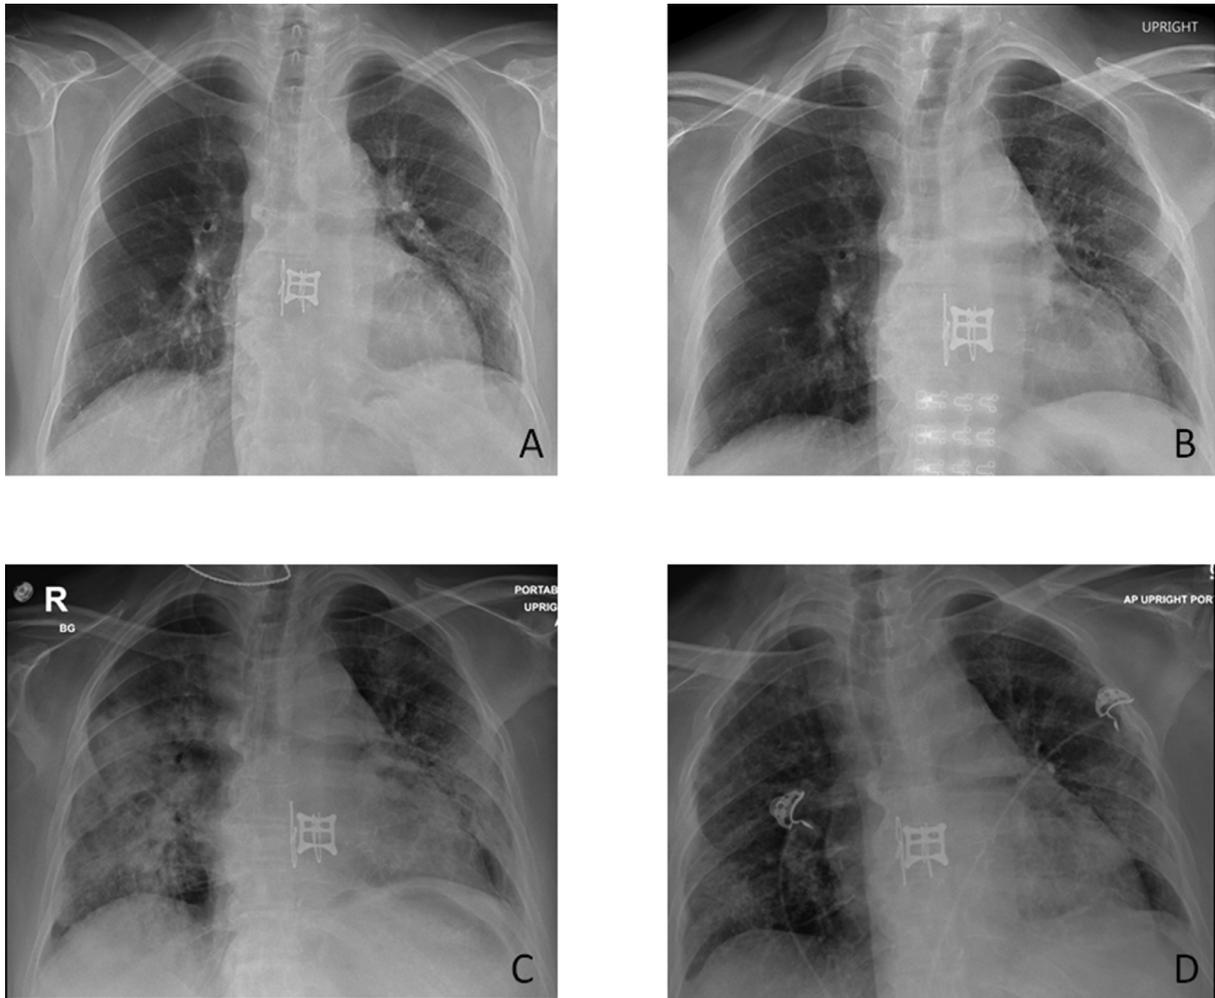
Serial chest radiographs of a 66/F bilateral lung transplant patient with COVID-19 infection. She presented with cough, sore throat and myalgias for 3 days. She had chronic kidney disease and creatinine peaked at 1.81 mg/dL during the illness. Chest radiographs were unremarkable at presentation (A). She was treated with remdesivir, oral prednisone taper, convalescent plasma and oral levofloxacin with improvement in her symptoms. She was discharged with stable spirometry and good oxygen saturations on room air after 6 days (B). She presented to the emergency room 8 days later with worsening shortness of breath and noted to be hypoxemic. She was admitted to the floor and started back on remdesivir, IV antibiotics and pulse corticosteroids. Over the next 48 hours, patient continued to worsen with increased oxygen needs and worsening opacities (C) culminating in mechanical ventilation, paralytics and prone positioning. She was continued on the same regimen and started to improve 3 days later with eventual extubation. Patient was weaned off oxygen although radiograph two weeks later showed overall much improved but persistent bilateral lower zone opacities (D).
